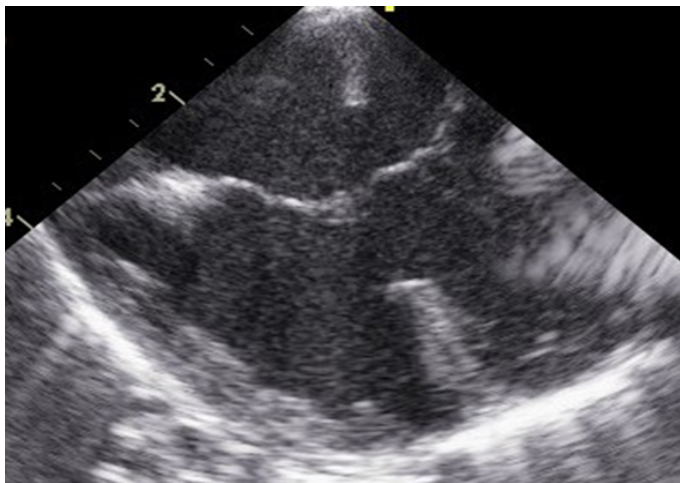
Transesophageal echocardiogram of twin 2 showing a wide Ostium Primum ASD, Ostium Secundum ASD, a patent foramen ovale, a wide inlet VSD and a single AV valve.
